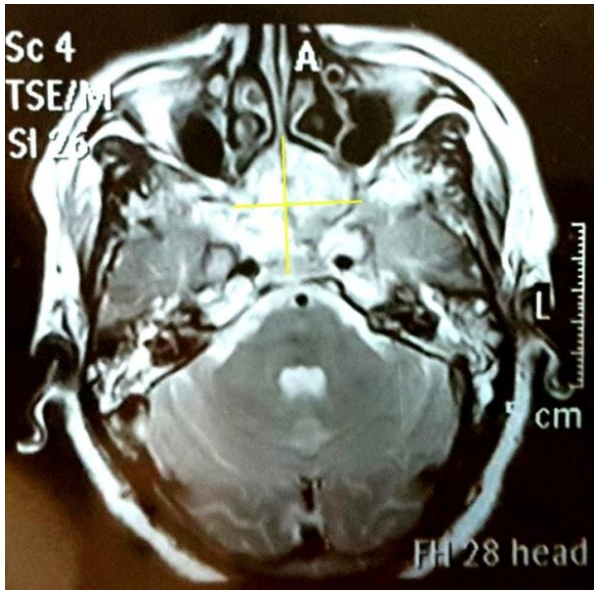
MRI of neck showing enhancing heterogeneous space occupying lesion extending from the naso- and oro-pharynx upto C2 vertebral level causing destruction of sphenoid sinus and clivus and abutting adjacent portion of internal carotid artery.
